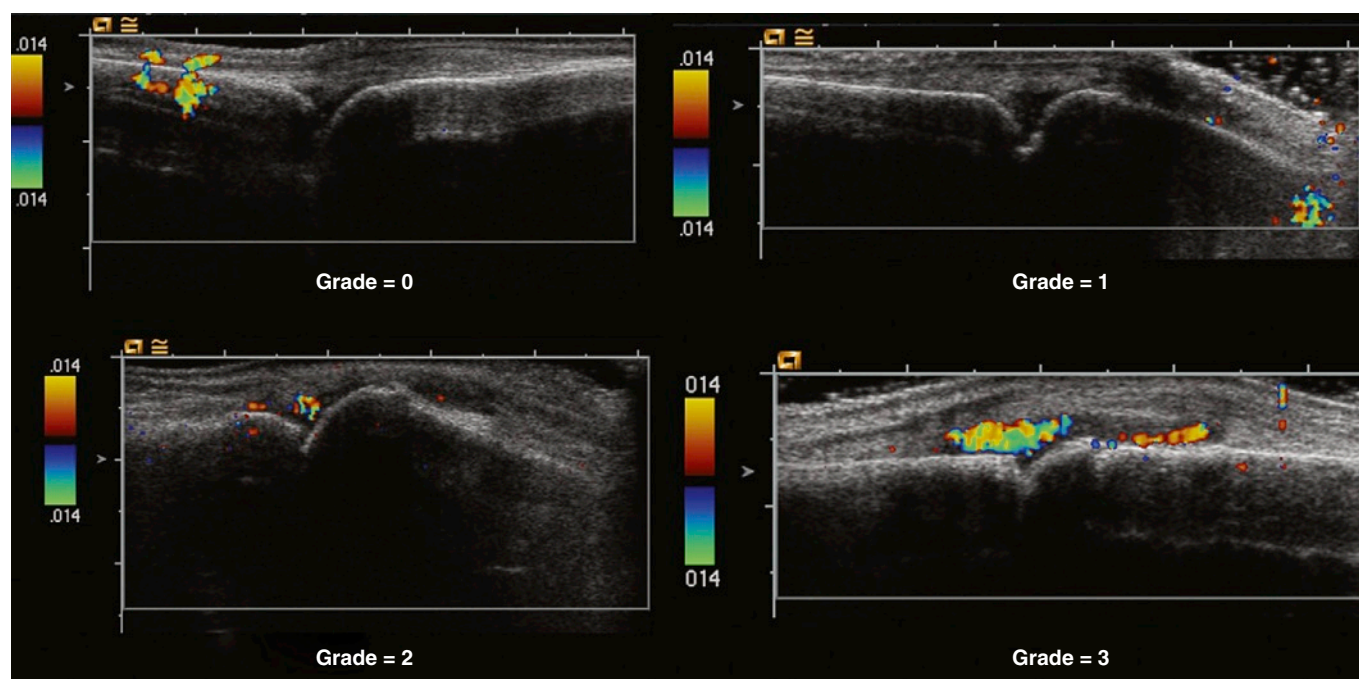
SEMIQUANTITATIVE SCORING SYSTEMS. Scoring systems are used to grade the Doppler signal: grade 0, no flow in the synovium; grade 1, single-vessel signals; grade 2, confluent-vessel signals in one half of the area of the synovium; and grade 3, confluent-vessel signals in more than one half of the area of the synovium.
